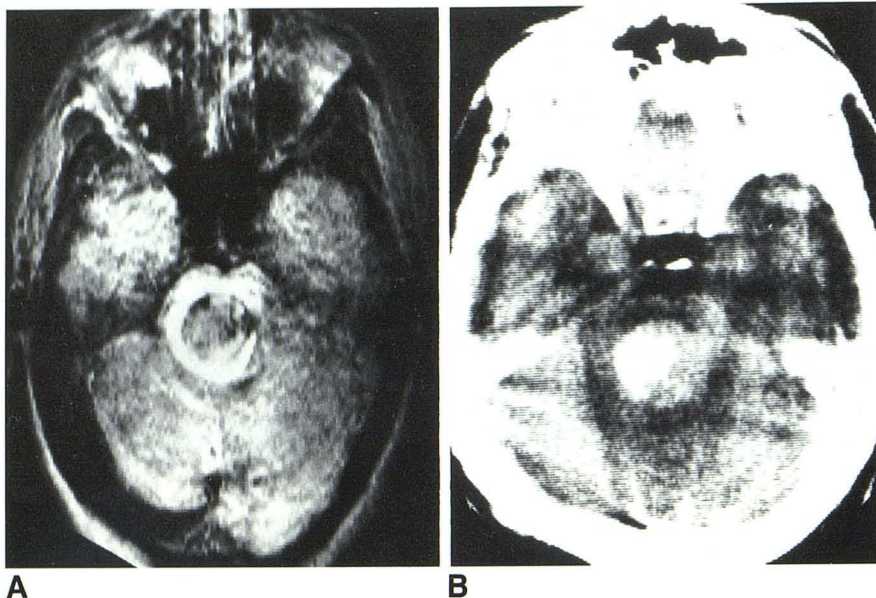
A, Axial SE 1000/90 image. Central region of normal signal surrounded by rim of increased signal. B, Nonenhanced CT scan. Center contains calcification.
